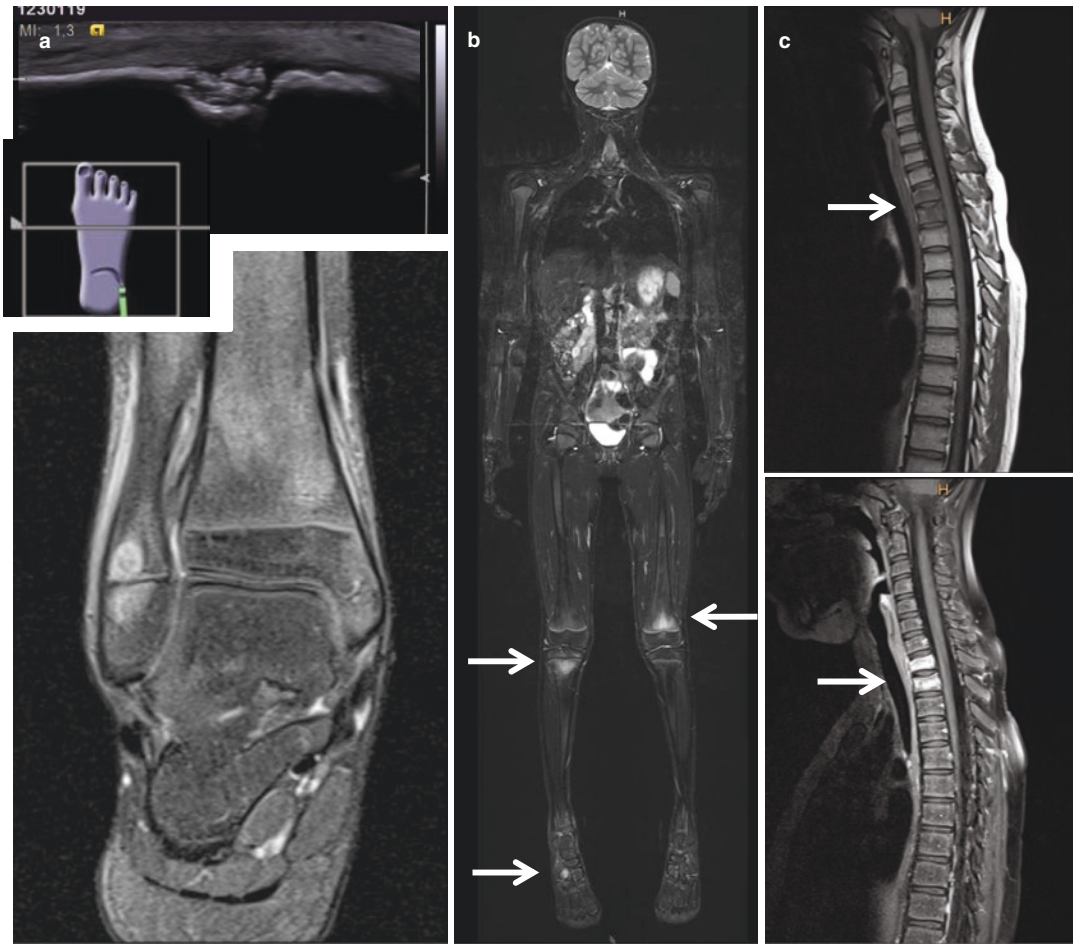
Imaging findings in patients suggestive of CRMO. (a) Ultrasound in a 6-year-old patient with swelling and warmth over the lateral right ankle showing cortical incongruity. MRI scans (contrast enhanced coronal T1 sequences with fat saturation) unveiled enhancement in the metaphysis and epiphysis of the distal right fibula. (b) Coronal TIRM sequences in the same patients showed hyper intense areas in the distal femoral metaphysis of the left leg, the proximal tibia metaphysis and the tarsus on the right side. (c) MRI scans of the vertebral column in a
